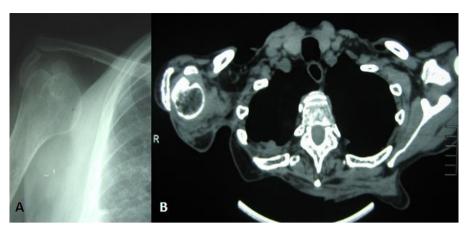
(A) Simple X-ray that shows the scapulectomy and the humeral suspension. (B) CT scan that shows the scapulectomy and the lack of reappearance after 5 years.
